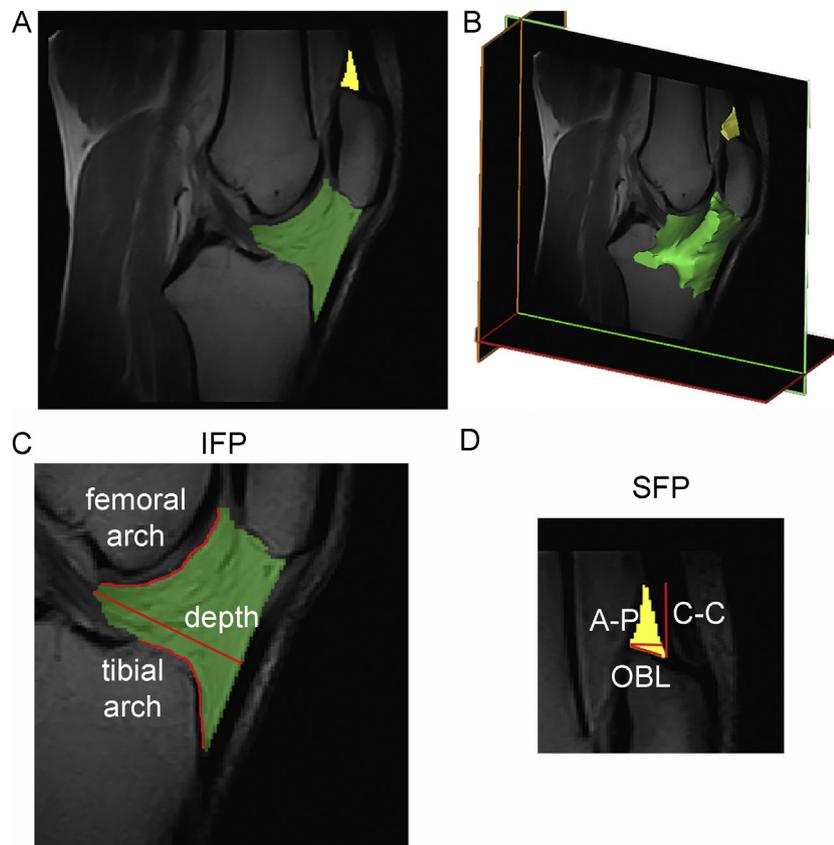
IFP (marked red under the patella) and SFP (marked area over the patella) masks (A) and volume identification (B) on MRI. Definition of depth, femoral and tibial arch lengths for the IFP (C) and of antero-posterior (A-P), cranio-caudal (C-C) and oblique (OBL) lengths for the SFP in the central slice (D).
